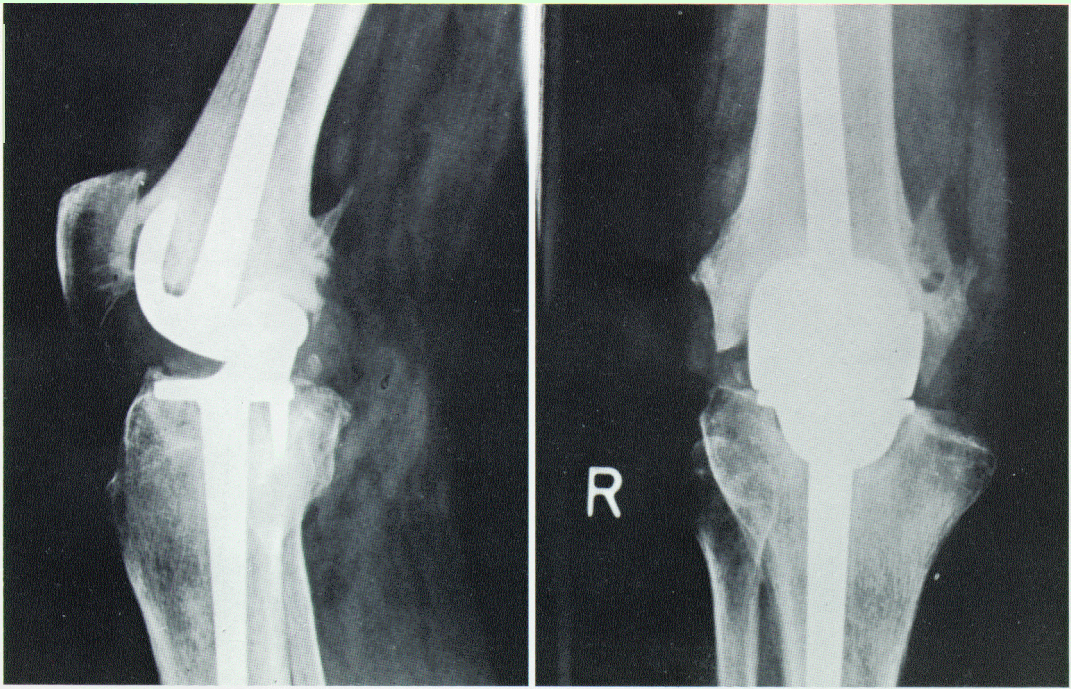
Case 4. X-ray: 9 months after implantation of an endoprosthesis.
